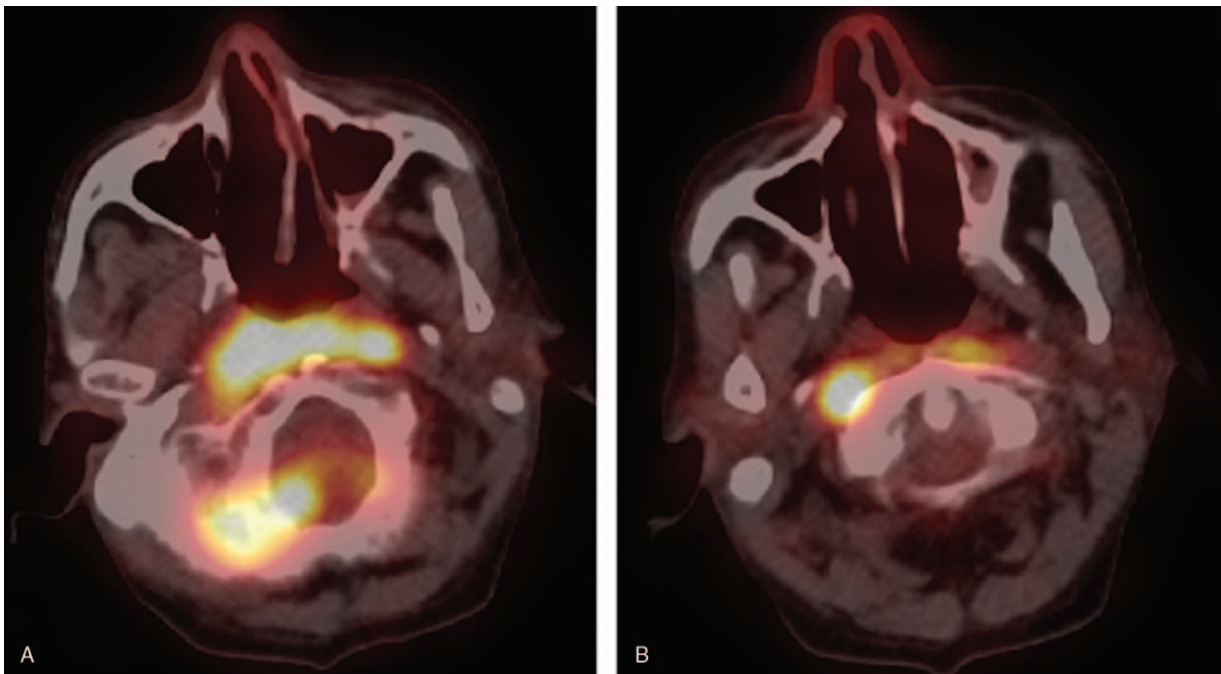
Positron emission tomography (PET) scan demonstrated an increased accumulation of FDG (2-deoxy-2- ^{18}F fluoro-D-glucose) in the thickening posterior pharyngeal wall (A) and an increased accumulation of FDG in the retropharyngeal lymph node (B).
